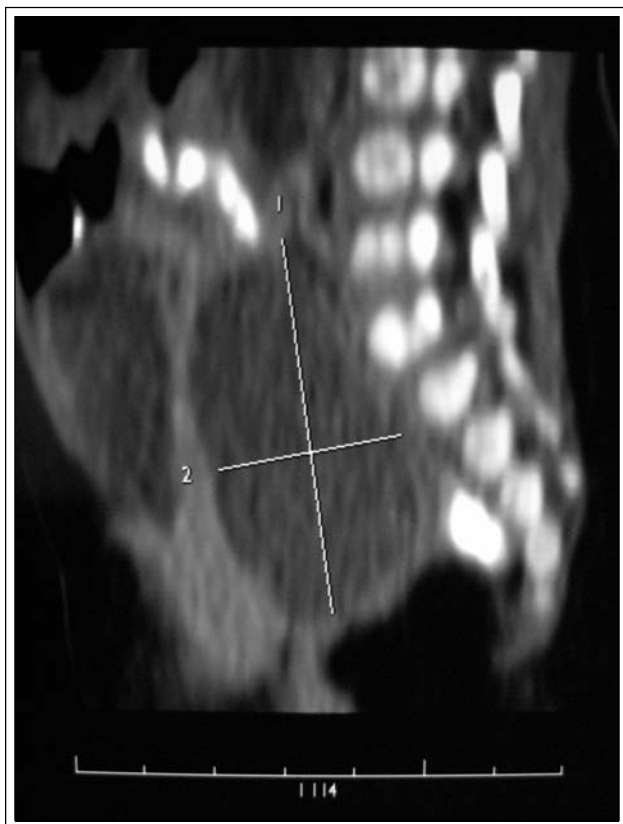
Pelvic CT 10 minutes post-contrast injection revealing a 5.2 cm x 4.2 cm fluid filled collection posterior to the bladder and anterior to the rectum seen in (a) axial and (b) sagittal views.
